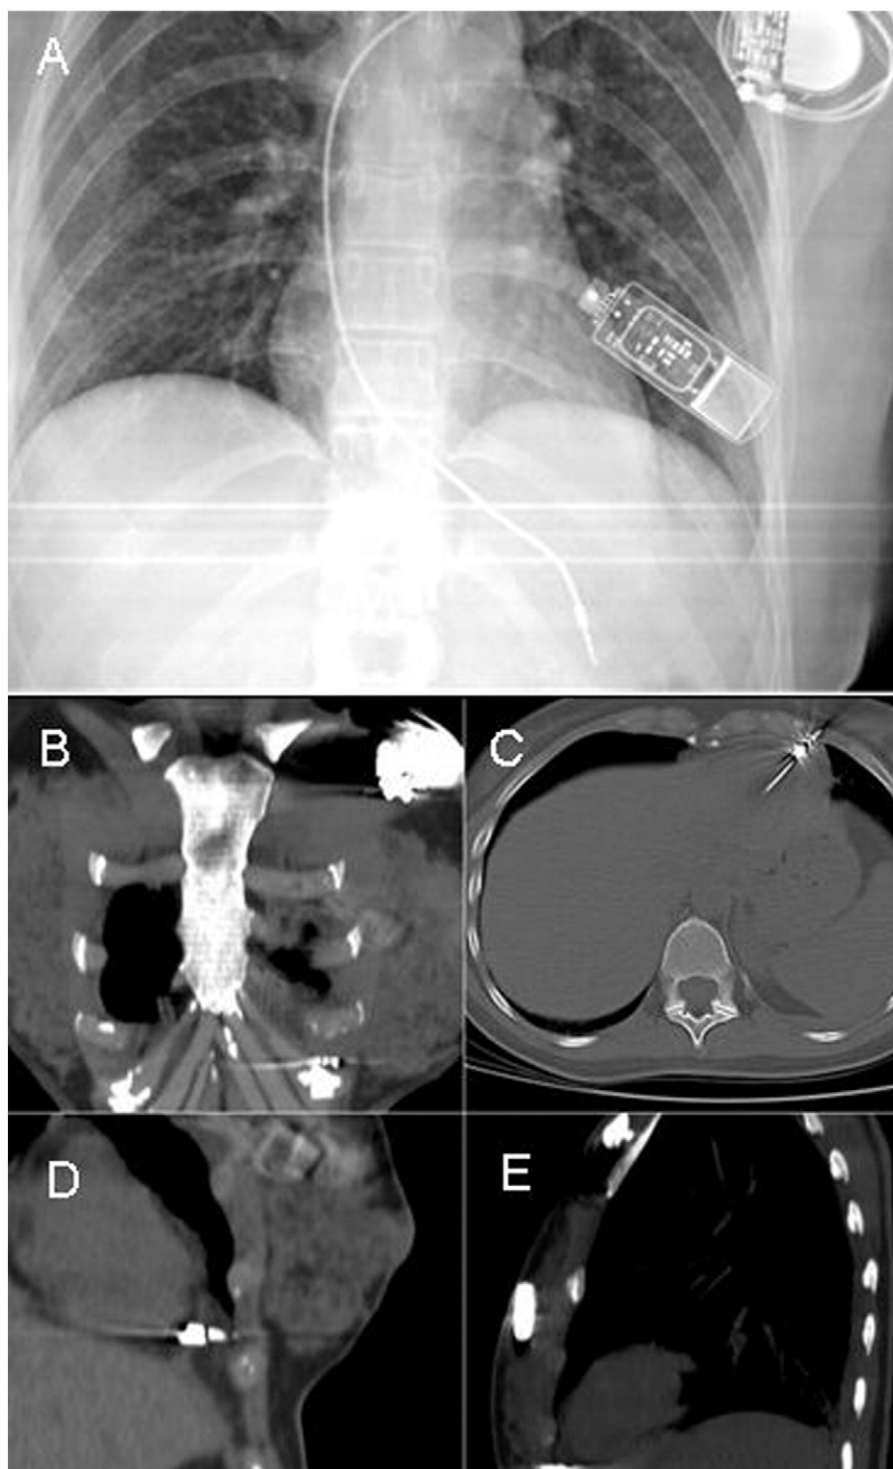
A chest X-ray (Panel A) and a computed tomography (Panels B, C, D and E) revealed a cardiac perforation of the right ventricle.
